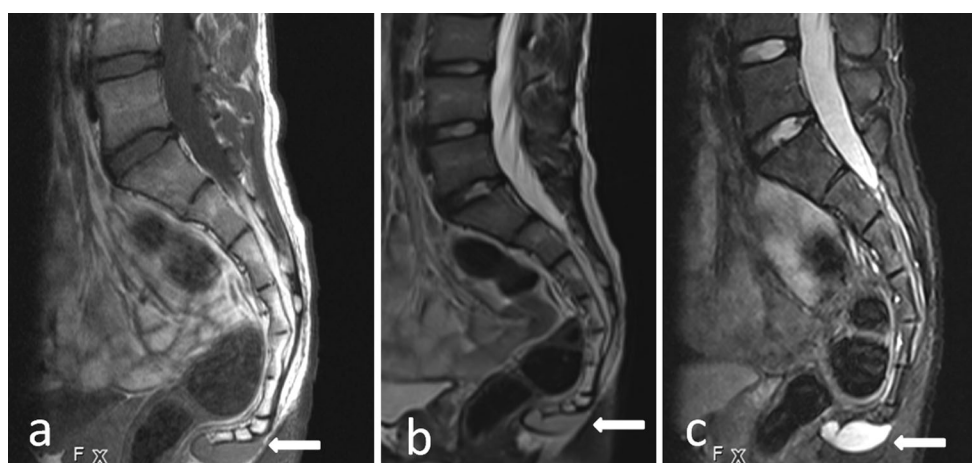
a T1-weighted MRI image showing isointense cystic lesion adjacent to coccyx (arrow), b MRI T2-weighted image showing hypointense cystic lesion adjacent to coccyx (arrow), c MRI STIR image showing hyperintense cystic lesion adjacent to coccyx (arrow)
